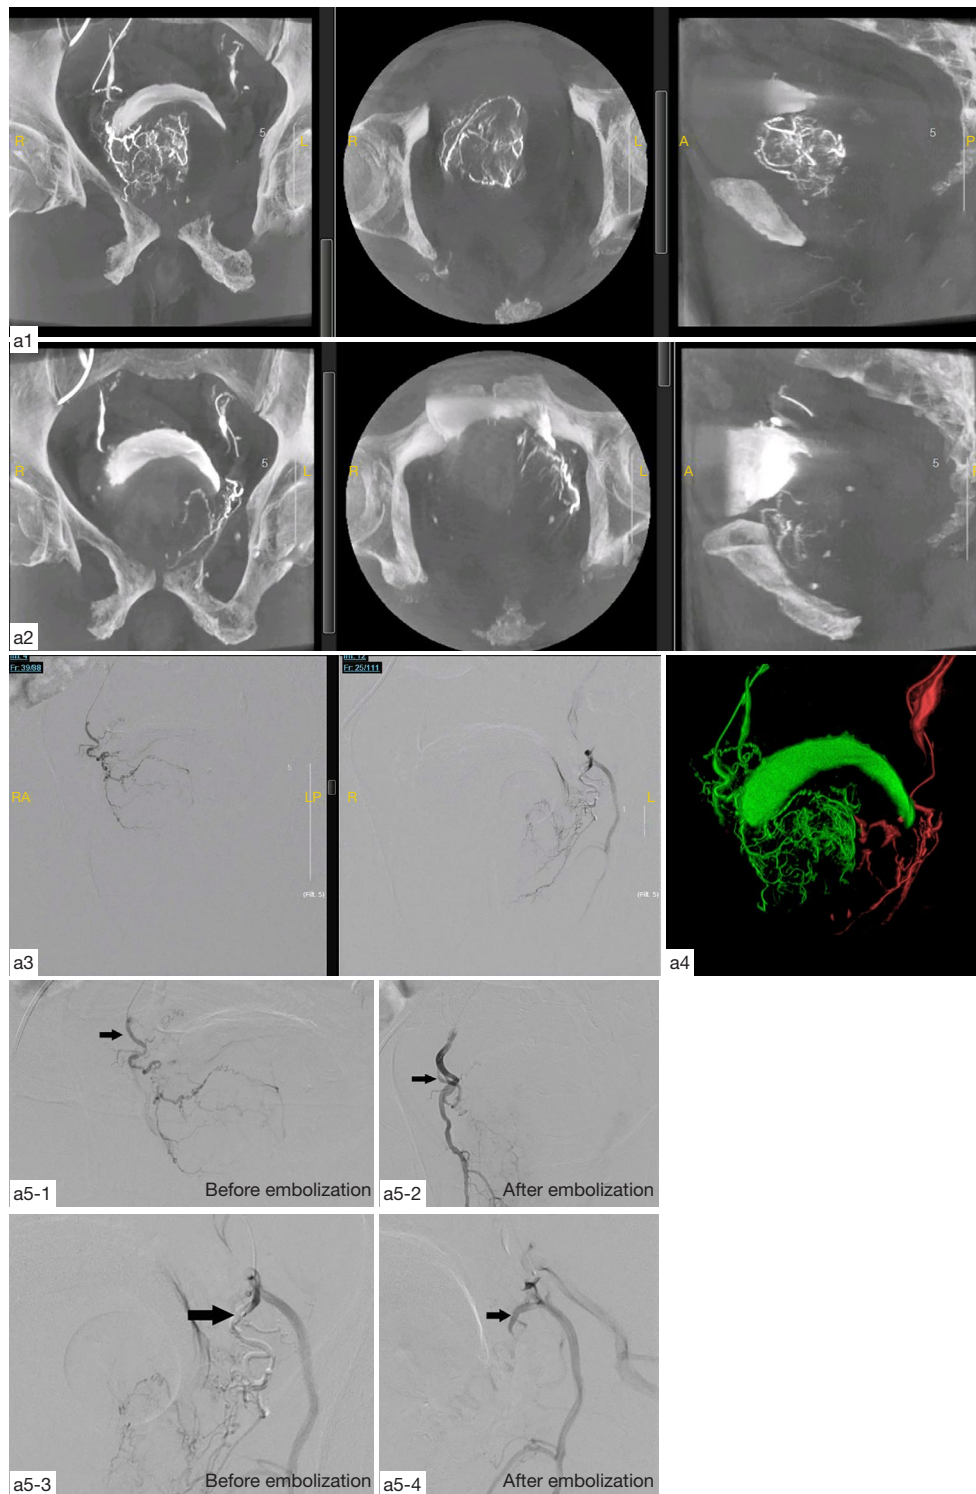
Intraoperative DSA and C-arm CT images, a1: C-arm CT of the right PA in the coronal, transverse and sagittal planes; a2: C-arm CT of the left PA in the coronal, transverse and sagittal planes; a3: bilateral PAs; a4: CBCT of the bilateral PAs (VR); a5-1-2: DSA images of the right PA before and after embolization; a5-3-4: DSA images of the left PA before and after embolization; the black arrows indicate the prostate artery. PA, prostate arteries; DSA, digital subtraction angiography; CBCT, C-arm Bundle Computed Tomography; A, ahead; P, post; R, right; L, left; RA, right ahead; LP, left post.
